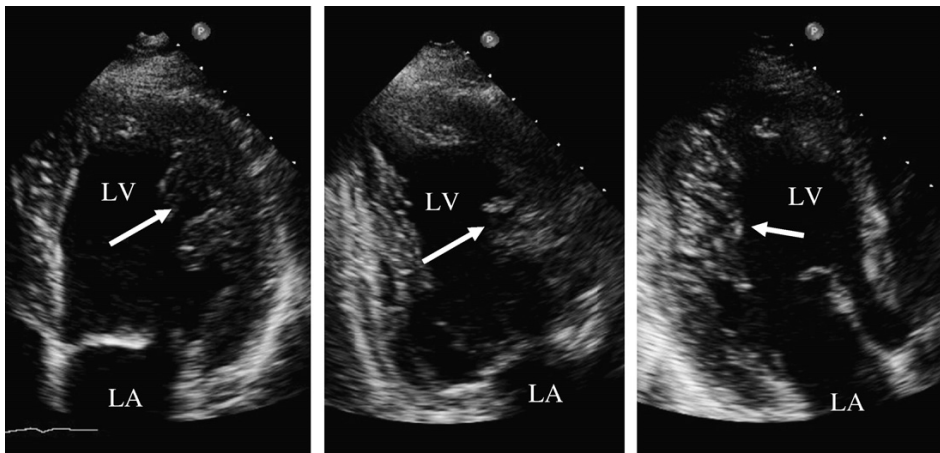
Two-dimensional echocardiogram (apical 4-chamber, left; 2-chamber, middle; 3-chamber, right) showing prominent trabeculations and recesses in a patient with a noncompacted left ventricle (arrows). Abbreviations: LA = left atrium, LV = left ventricle.
